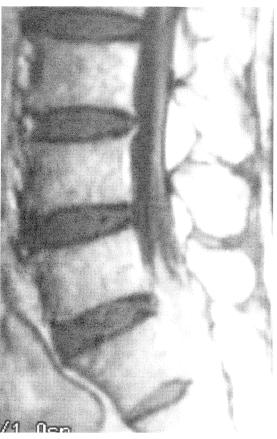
MRI showing the intrathecal tumour extending from vertebra L5 to S2.
